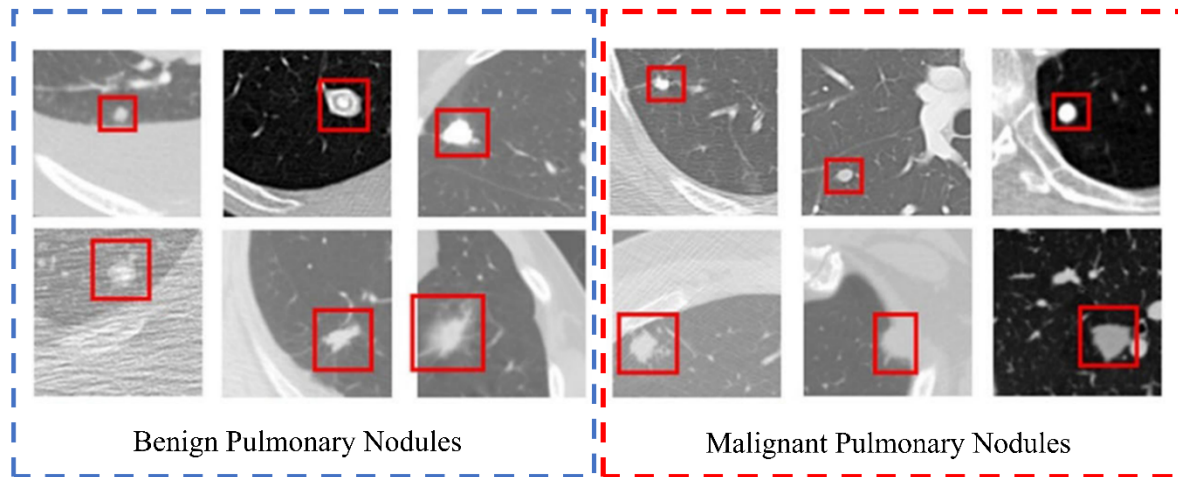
Display of benign and malignant pulmonary CT nodule image samples.
